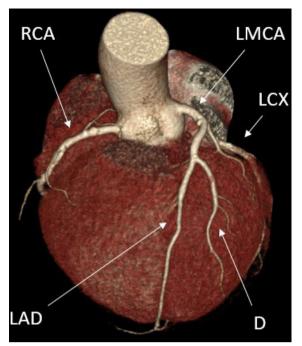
The figure displays a coronary CT angiography. A semiautomatic programme detects non-calcified coronary plaque. CX, circumflex artery; D, diagonal branch of LAD; LAD, left anterior descending artery; LMCA, left main coronary artery; RCA, right coronary artery.
